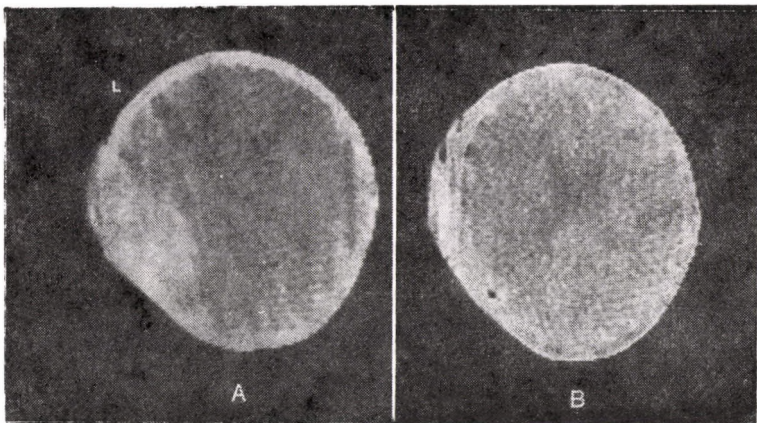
CT of a 3-year-old boy. The big, left temporal haematoma is well demonstrated by CT. Urgent surgery followed the CT. A. Before surgery, B. After surgery
